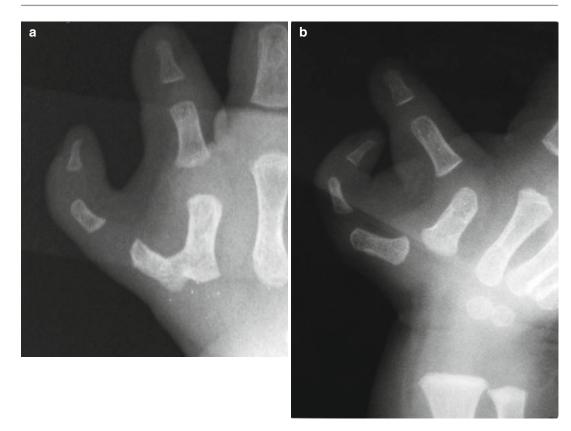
Radiographs of type 5 and 6 radial polydactyly. The PA view is carefully examined to evaluate the bone alignment. (a). Type 5 polydactyly shows the ulnar digit
